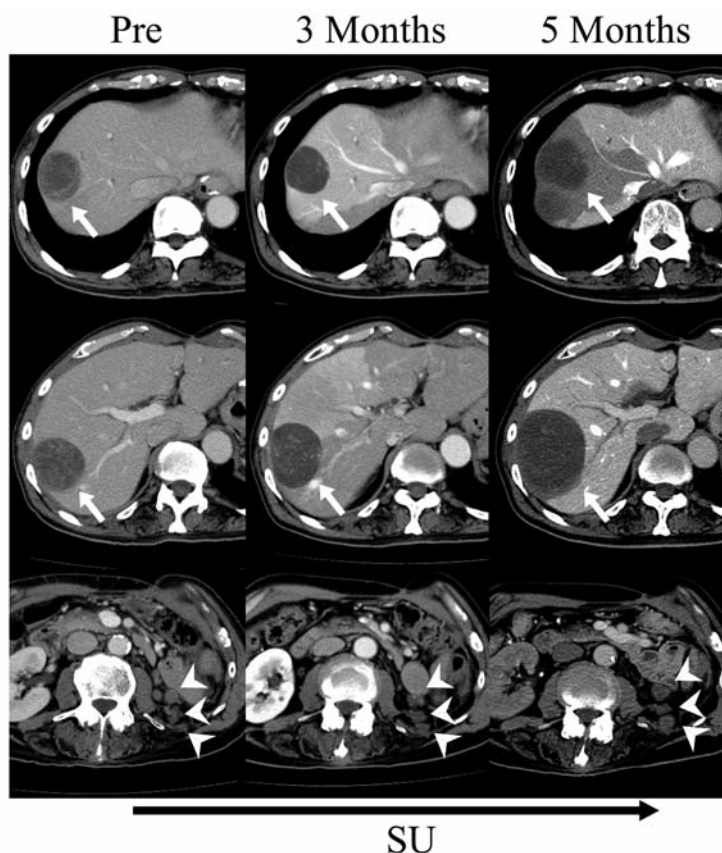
Computed-tomographic (CT) scans of the abdomen before (left panel) and after (middle and right panels) sunitinib (SU) treatment. There are multiple liver metastases in the right lobe (top and middle panels, arrows), one of which was sensitive (top panel) and the other of which was resistant (middle panel) to sunitinib. Recurrent tumors were seen in the retroperitoneal space (bottom panel, arrowheads).
